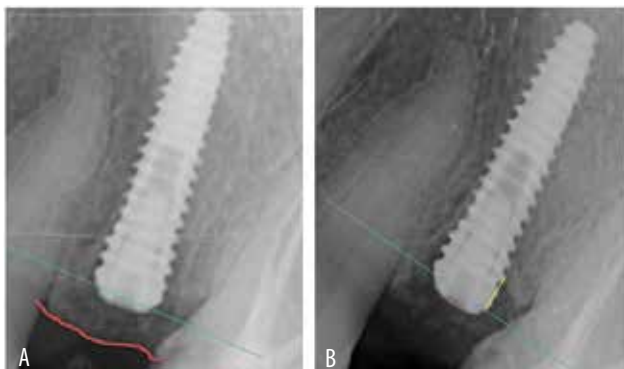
Digital radiograph scan: baseline digital periapical x-ray (A), 6 month digital periapical x-ray (B).
